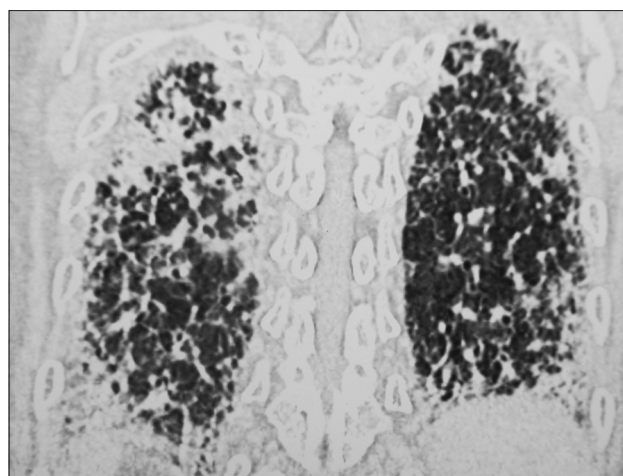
Post treatment computed tomography scan chest, lateral sagittal view
